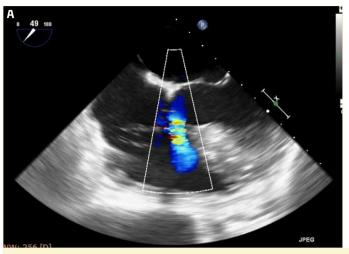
(A) Transesophageal echocardiographic view of the ventricular septal defect. (B) Chest radiography showed pulmonary congestion.
